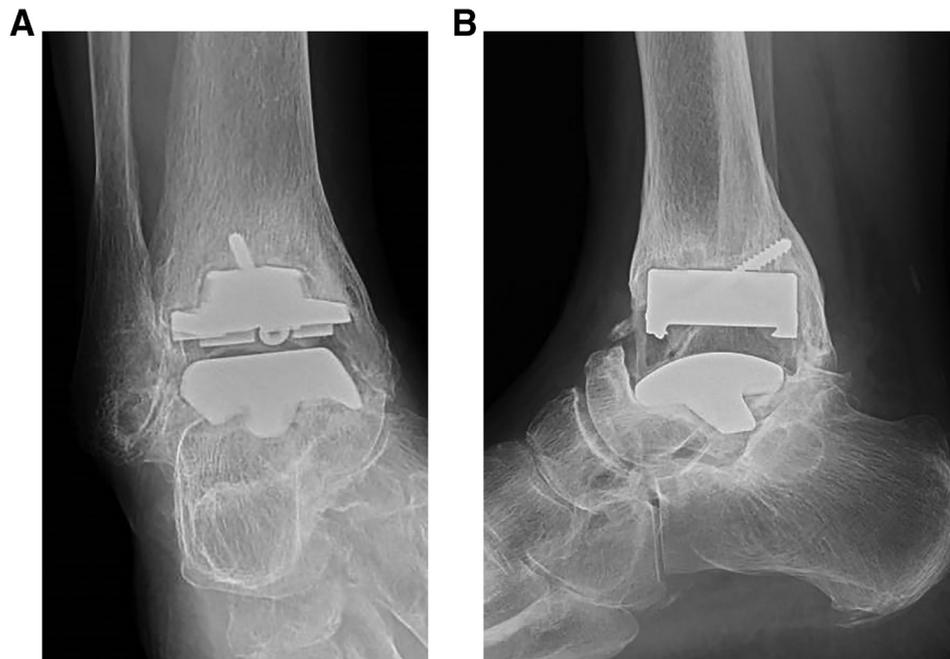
Radiographs taken at 7 years after primary total ankle arthroplasty. (A) Anteroposterior; (B) lateral. The talar component subsidence and radiolucent line around the tibial component are visible.
